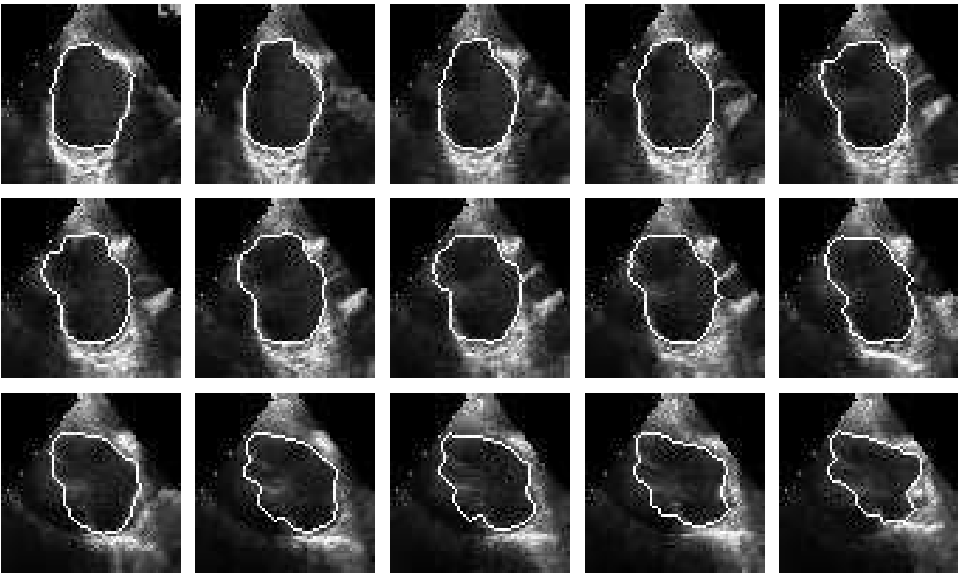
Contour tracking in 3D ultrasound echocardiography. The sequence goes from left to right and top to bottom.
